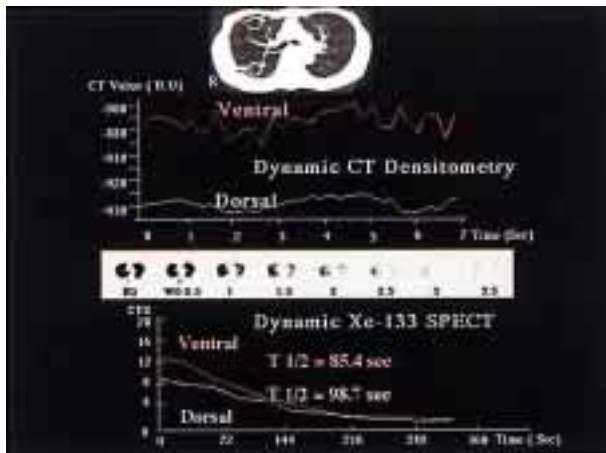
Dynamic expiratory spiral CT with ROIs at the middle lung zone, and pulmonary densitometry (PDD) in a 57-year-old man with pulmonary emphysema. A chest CT image (top) shows patchy hyperlucency diffusely in both lungs. The PDD (the 2nd line) shows flattened and irregular curves in both the right ventral and dorsal lungs. ^{133}Xe SPECT images (3rd line) shows abnormal ^{133}Xe retention in both lungs. ^{133}Xe clearance curves (bottom) shows more prolonged ^{133}Xe clearance in the right lung area with more reduced respiratory changes in CT attenuation. H.U. = Hounsfield units, CPS = counts per second.
